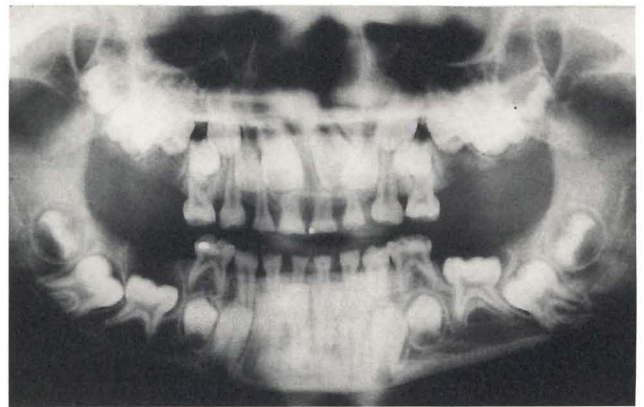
Orthopantomograph of same girl show all second primary molars deeply impacted in the jaw. The lower permanent first molars are locked below the distal curvature of the primary molars. Agenesis of all second premolars.
